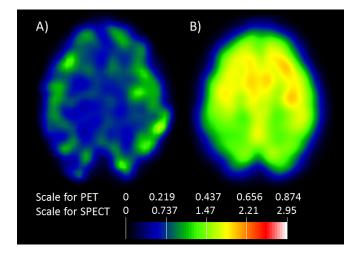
Axial view of realigned emission images used in PIS-COM analysis. Ictal SPECT level high (A) and preprocessed PET (B).
